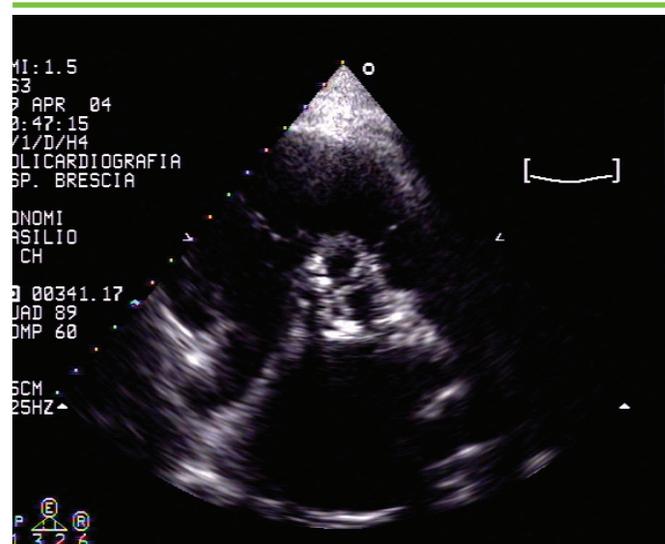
2D parasternal short axis view. Calcific aortic wall without stenosis. The aortic cusps are thickened for sclerosis and calcium deposition, although systolic opening is preserved.
